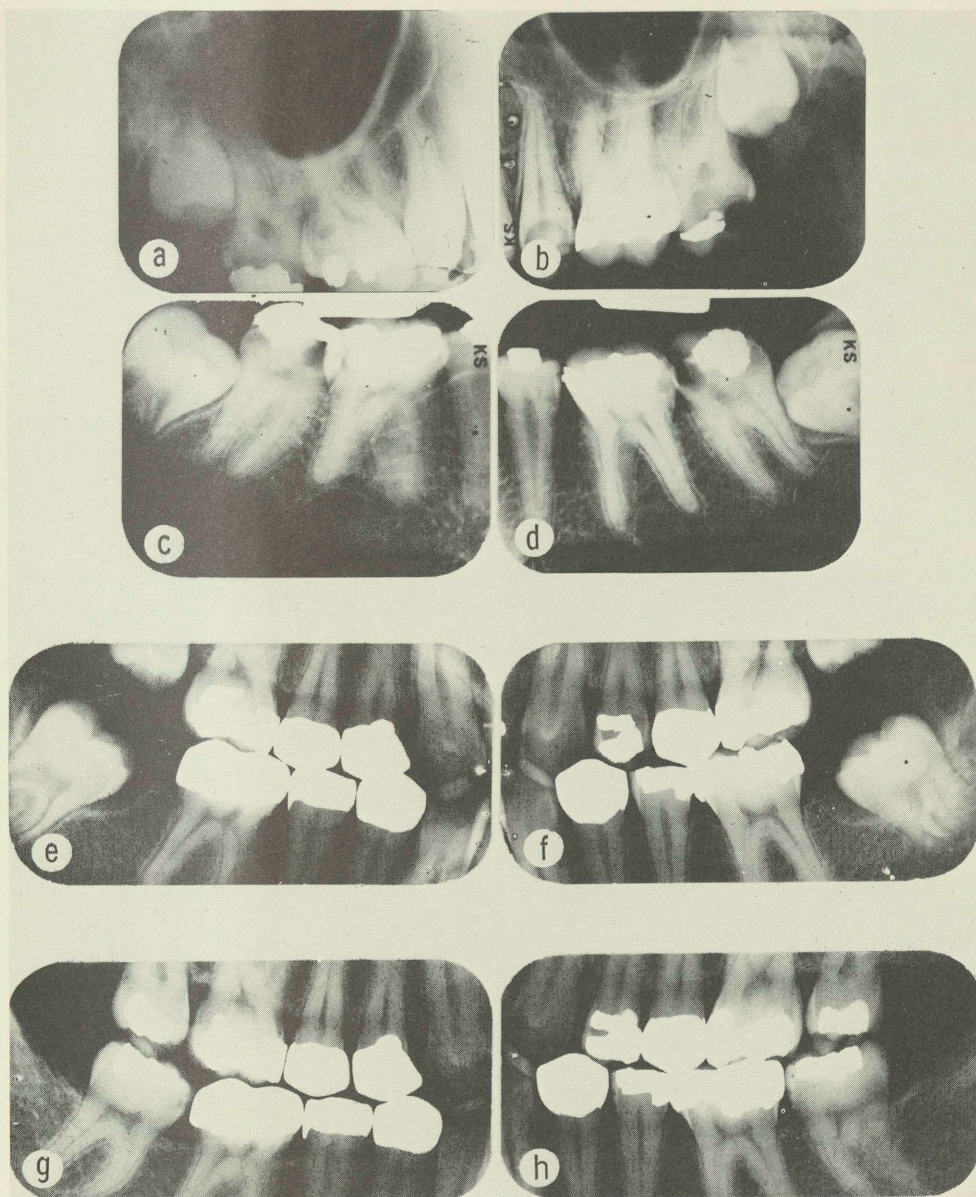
(a-b-c-d)—Periapical radiographs show the presence of normally shaped, open rooted third molars possessing much eruptive force.
